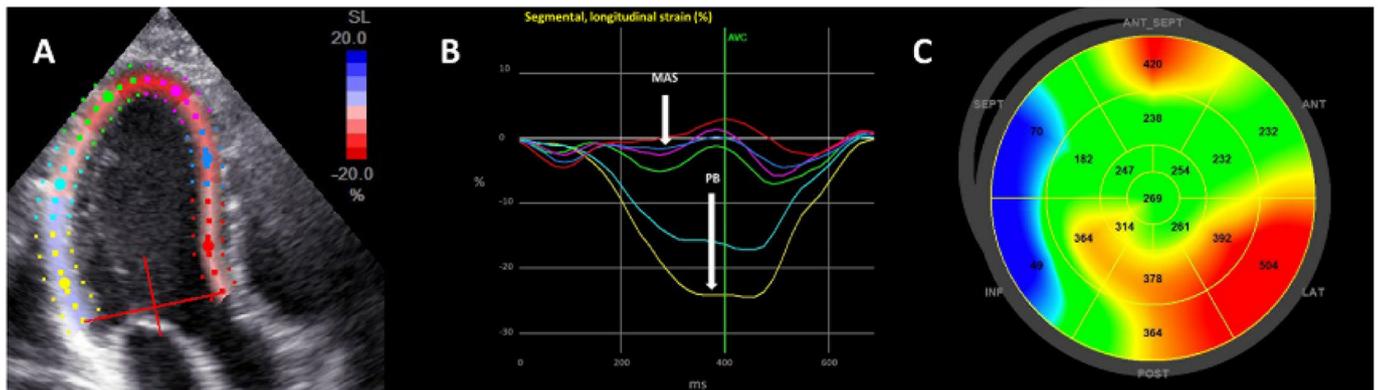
Speckle tracking echocardiography to assess the risk of ventricular arrhythmias. Panels A & B: Impaired antero-septal strain in the territory of a left anterior descending coronary artery infarct. Longitudinal strain is measured with 2-dimensional speckle-tracking echocardiography in the apical 3-chamber view (A). Different colors represent different segments, e.g. the mid-anterior segment in dark blue and the posterobasal segment in yellow. The mid-anterior segment demonstrates impaired peak longitudinal strain, while the posterobasal segment shows evidence of compensatory hypercontractility (B). AVC: aortic valve closure; SL: longitudinal strain. Panel C: Mechanical dispersion of the left ventricle, displayed as a parametric map in a patient with ischemic cardiomyopathy. Late activation of the posterolateral segments (orange/red) results in an abnormally elevated mechanical dispersion of 121 ms.
